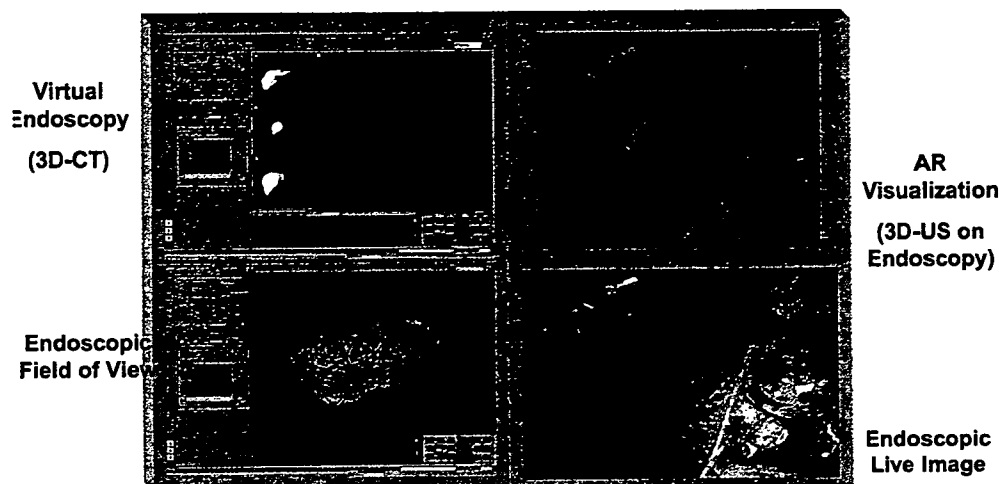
Integrated display of navigation system based on 3D-CT and 3D-US with calibration system of oblique-viewing endoscope. *Upper left figure* shows structures in a liver constructed from preoperative CT images, and *upper right figure* represents AR visualization that presents
